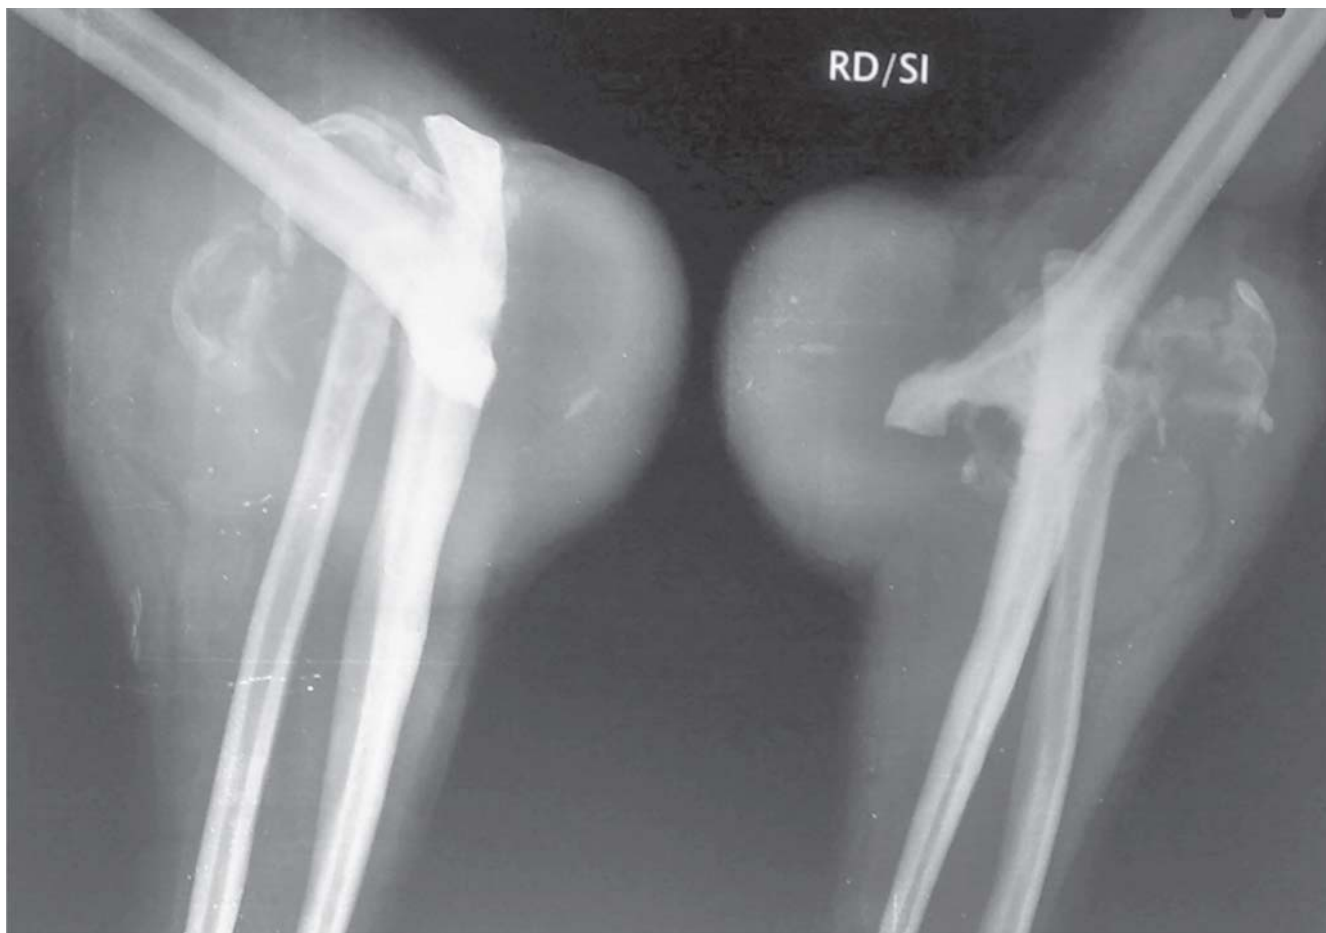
Pre-operative X-ray showing asymmetric and severe destruction of elbow joint.
